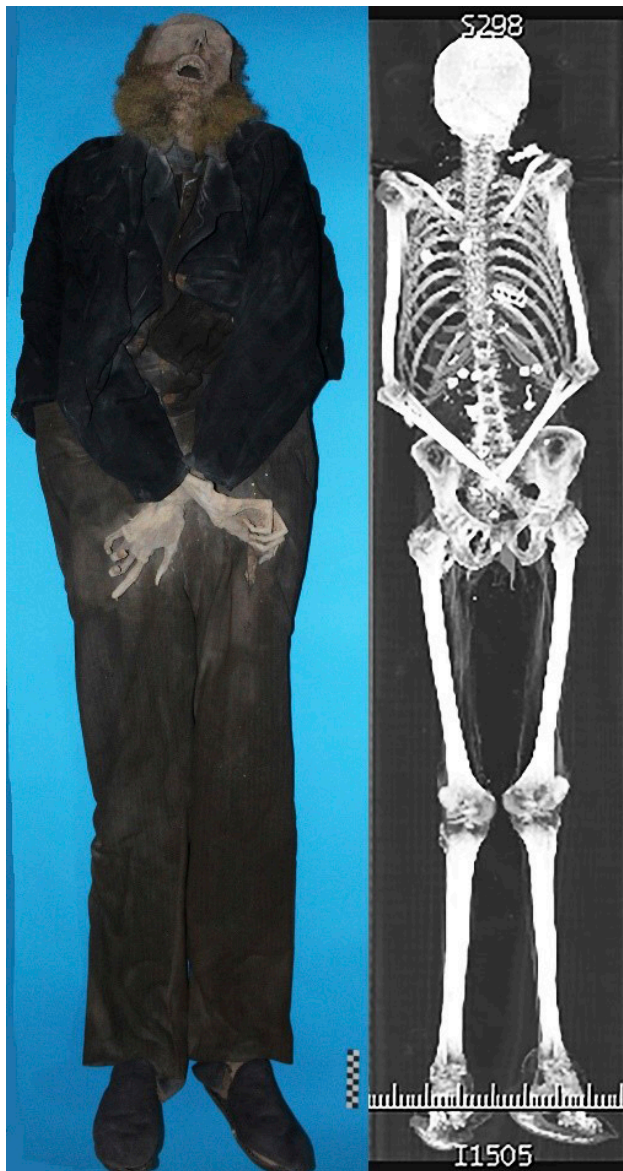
The body of MSA1 after superficial cleaning and its preliminary antero-posterior CT scout image.
